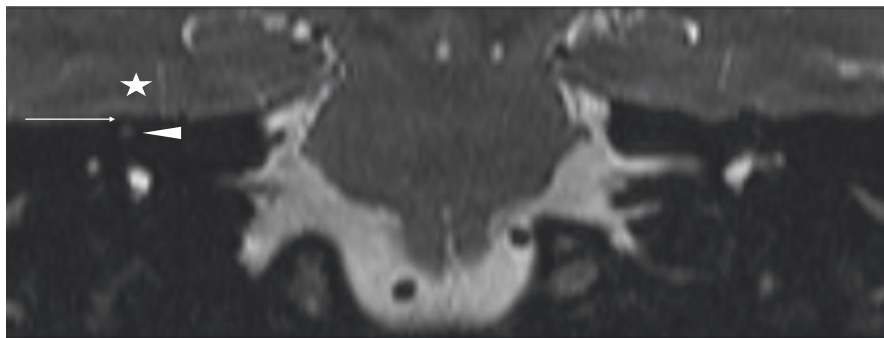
Coronal T2 weighted MRI of the IACs demonstrating a T2 hypointense boundary (arrow) delineating the arcuate eminence of the superior semicircular canal (arrowhead) from the inferior right temporal lobe (star), effectively excluding dehiscence at the arcuate eminence
